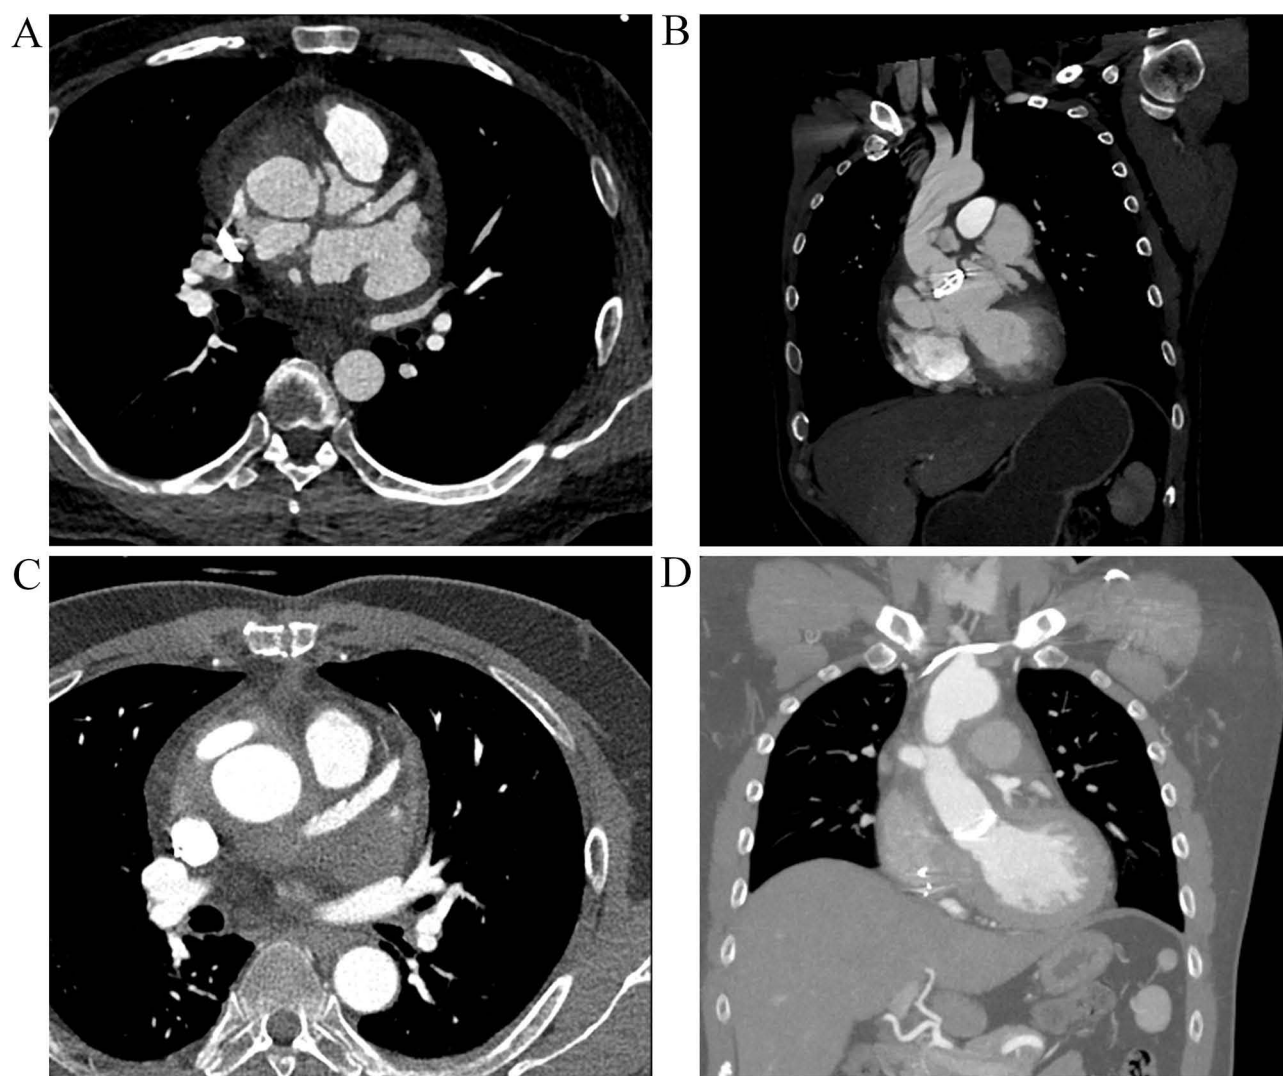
Computed tomography (CT) scans were performed during both the infection and recovery stages. (A and B) During the infection phase, CT revealed left ventricular enlargement and mild pericardial effusion. (C and D) During the recovery phase, the aortic valve orifice was free of obstruction, and there was a decrease in the accumulation of fluid in the pericardial cavity.
